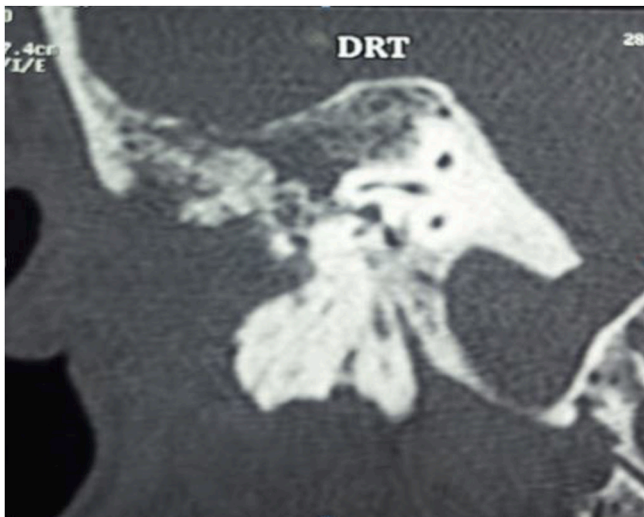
Computed tomography showing a pseudopagetoid reorganization of the texture of the whole of the petrous bone.
